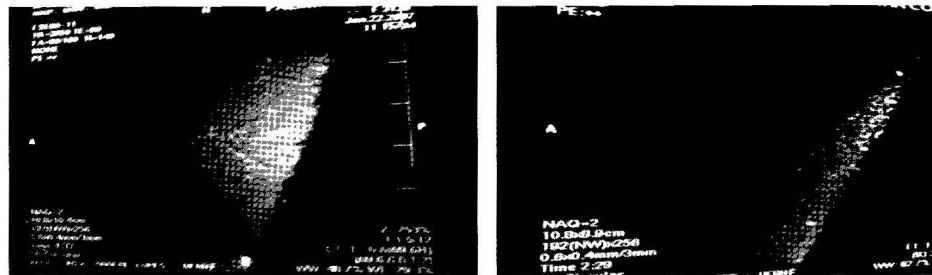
Sagittal plane T2-weighted pre and post-treatment image of patient 3.
